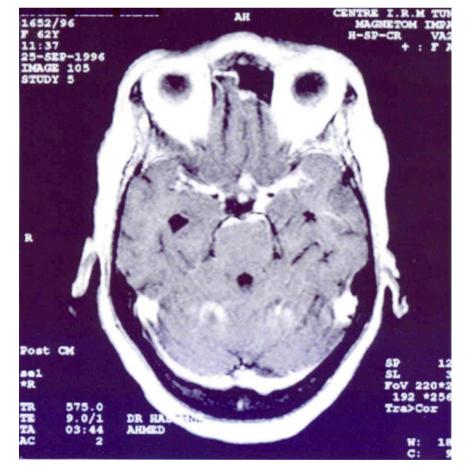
Axial T1-weighted MR image after administration of iv gadolinium showing basilar meningeal enhancement with tuberculomas of the olfactory bands and two cerebellar lesions.
